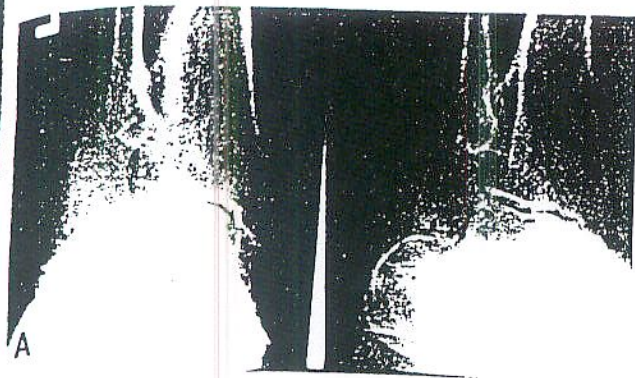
Preoperative ankle radiograph demonstrating post-traumatic fracture deformity. A, Anteroposterior view noting ankle with valgus position, distorted lateral malleolus, and fusion of the fibula to the tibia; B, lateral projection noting deformities at ankle and subtalar joints with joint depression of the latter and obliteration of Böhler's angle.
